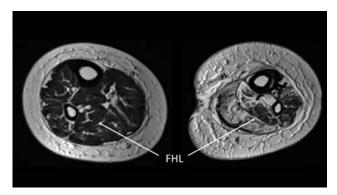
MRI comparison of the muscles of the right and left lower leg. Note global degeneration of the muscles sparing the FHL and FDL.
